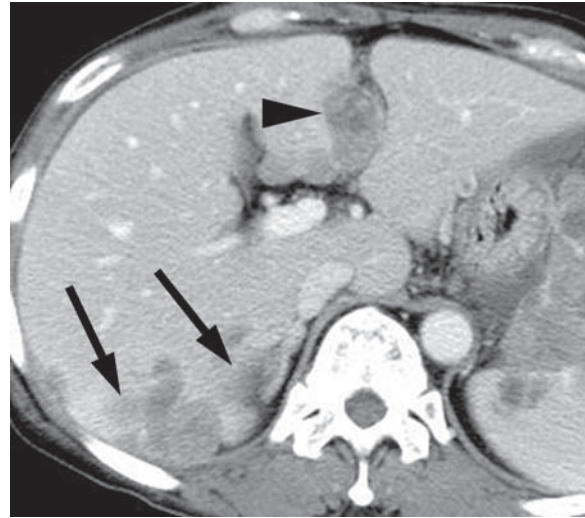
Capsular implants in a 52-year-old woman with ovarian cancer. Contrast-enhanced CT scan shows multiple tumor implants in the liver capsule (arrows). Note that part of the mass extends along the falciform ligament (arrowhead).
